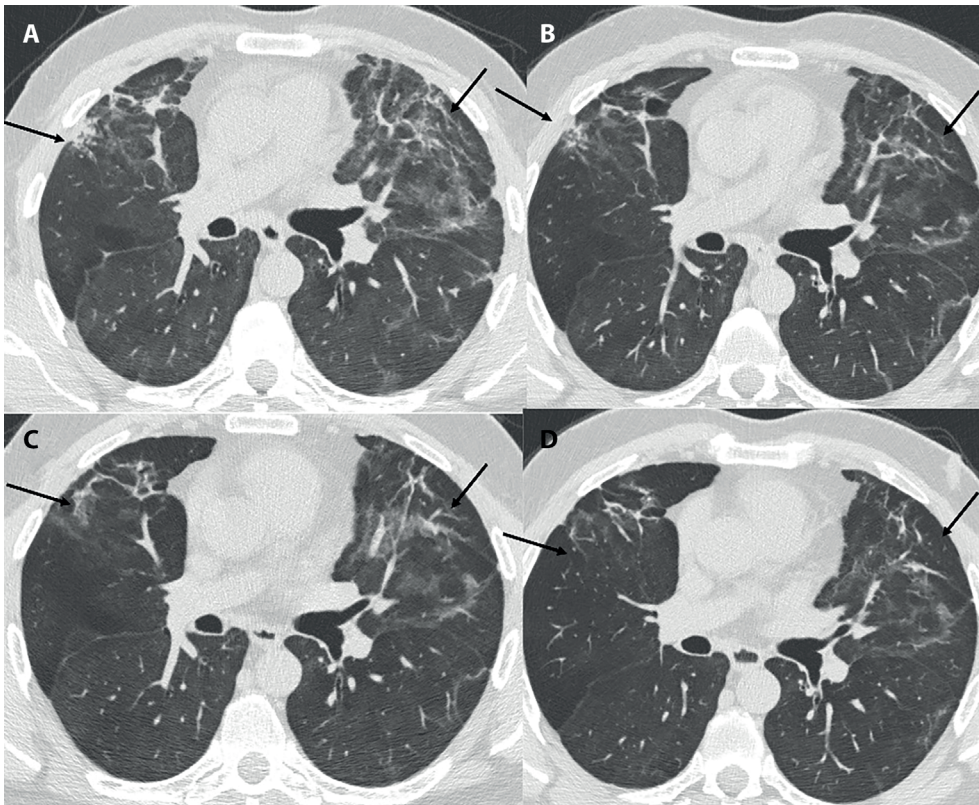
High-resolution computed tomography images passing through the subcarinal level of a 66-year-old male patient. A: before treatment, B: 1 month after immunosuppressive therapy, C: 3rd month, and D: 6th month. It is observed that reticulations gradually decrease with treatment (black arrows).
